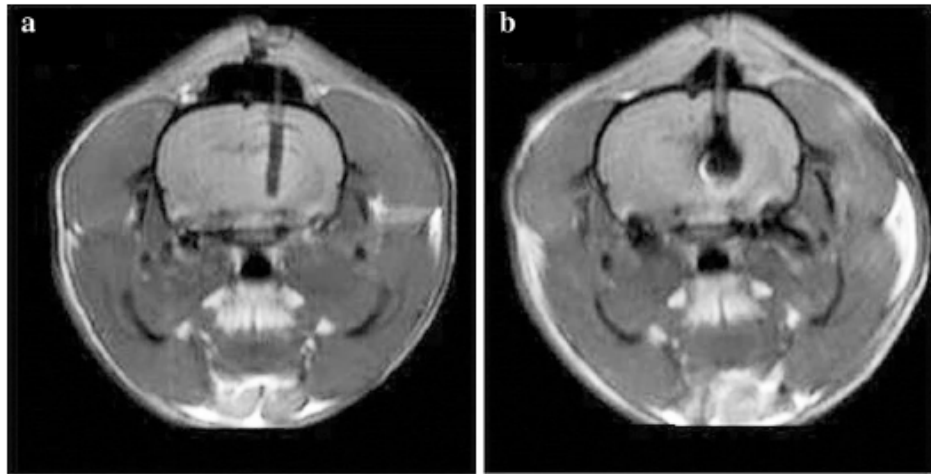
An example of MRI artifacts comparison of CNT fibers wrapped to a 1.3 mm tube and PtIr electrode. Figure from [68]
